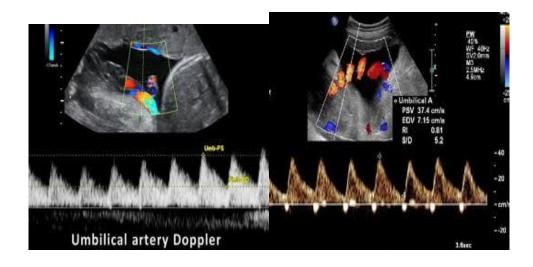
2.11 the normal Doppler waveform.
